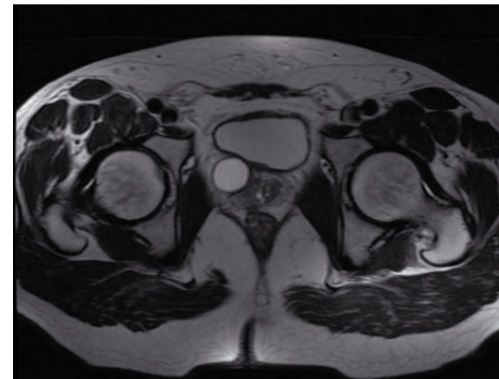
Pelvic MRI image of the seminal vesicle cyst
